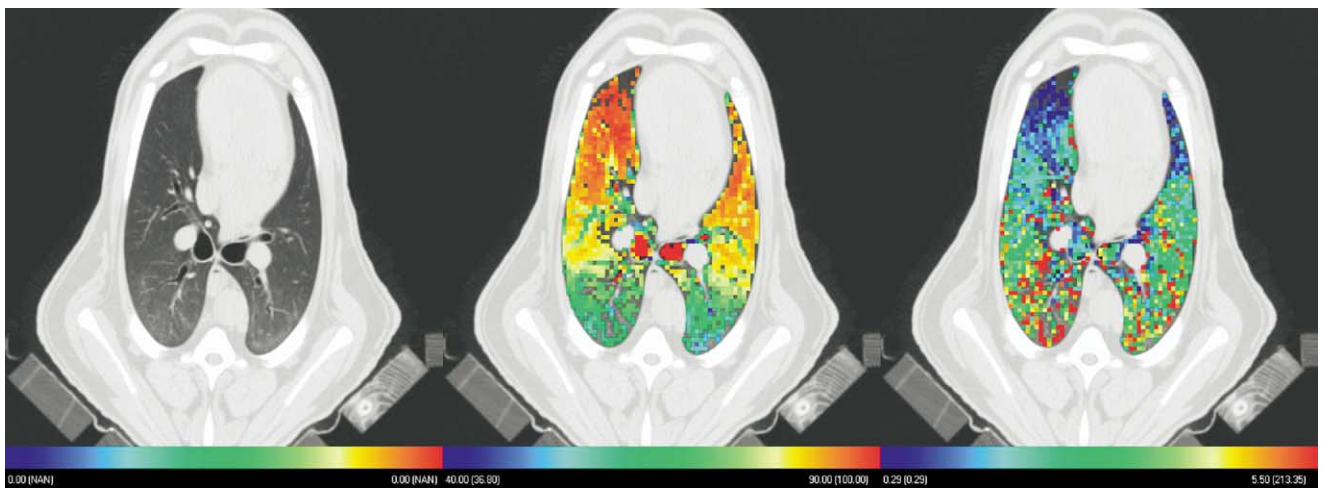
Regional Xe-CT analysis (ROI size, 8×8 pixels) for a slice at the level of the carina, showing (a) original gray-scale image and color maps of (b) regional air content (% air) and (c) specific ventilation (sec^{-1}).
